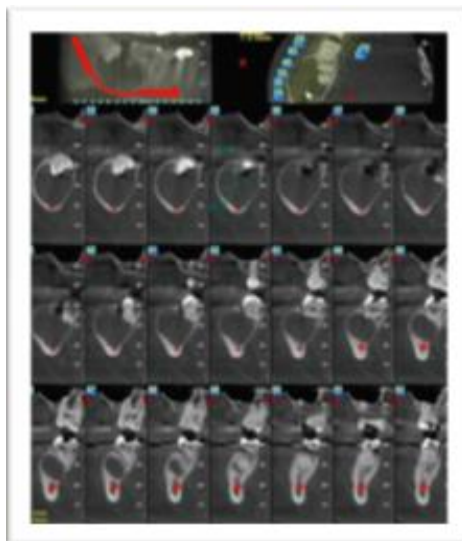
CBCT image showing expansion of buccal and lingual cortical plates, IANC is compressed and displaced inferiorly
